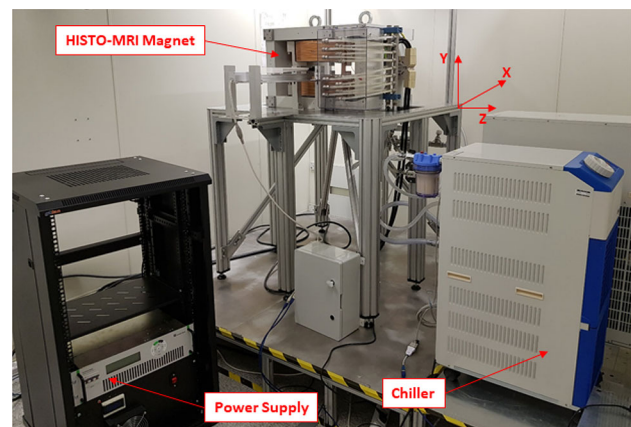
Picture of the HISTO-MRI system in the i3M and positioning system used in the magnetic characterization.
